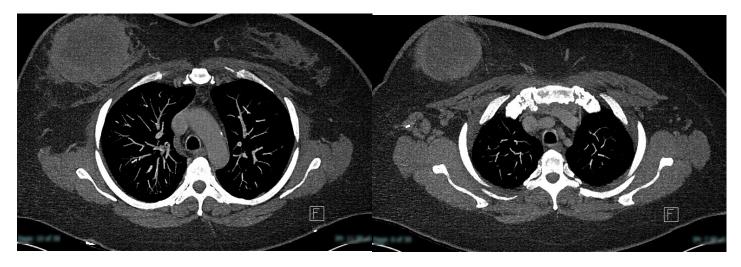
2021 CT Thorax with Contrast for staging of newly diagnosed breast cancer with (a) large heterogeneous right breast mass and (b) enlarged right axillary and subjectoral lymph nodes, demonstrating asymmetry to left side. Otherwise no CT evidence of distant metastatic disease within chest, abdomen or pelvis.
